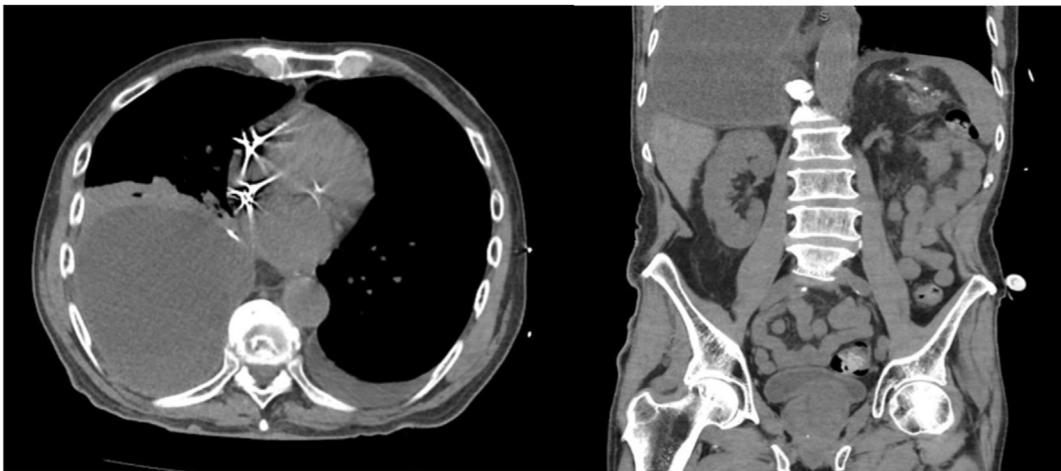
CT scan of the abdomen (transverse and coronal views) showing marked dilation of the distal portion of the gastric conduit.
